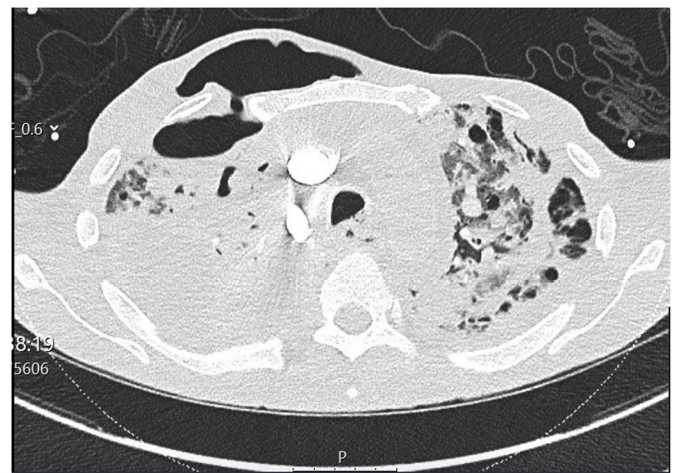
CT scan showing gas extending from pleural space to the right anteromedial chest wall.
